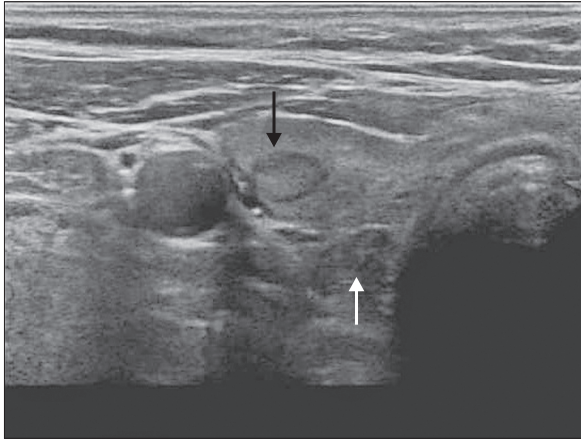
Preoperative neck ultrasound. Black arrow, thyroid adenoma; white arrow, parathyroid adenoma.
